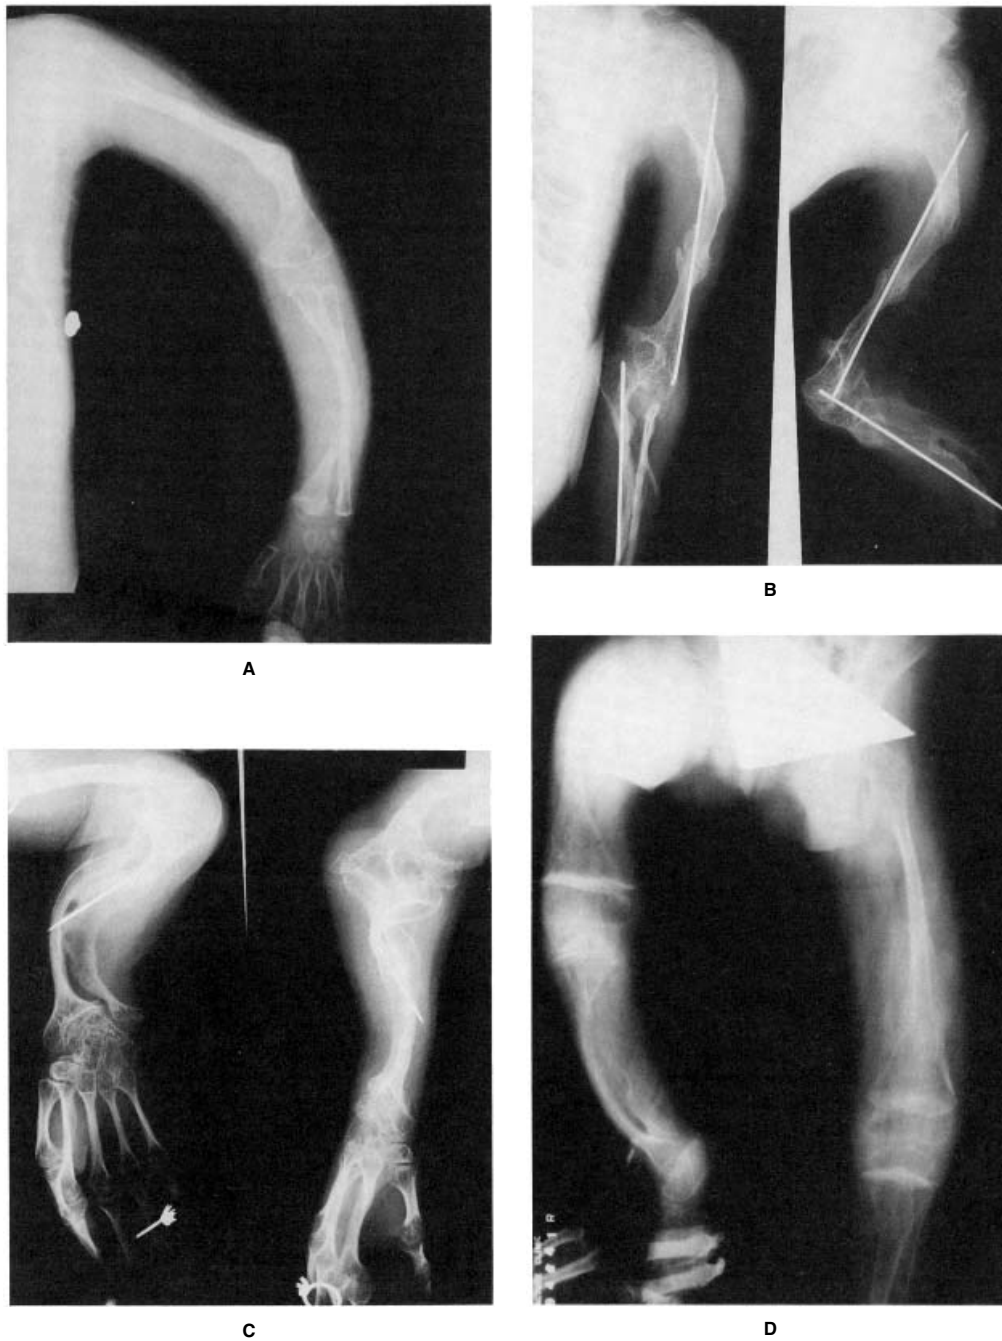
Progressively deforming nature of OI type III. The radiographs of the arms were taken at ages 2 years (A), 9 years (B), and 22 years (C), and those of the legs were taken at 3 years (D), 5 years (E), and 28 years (F). A and B are of the left arm, and C is of the right arm. The magnification of each radiograph is the same, indicating the paucity of growth of the long bones over many years.
